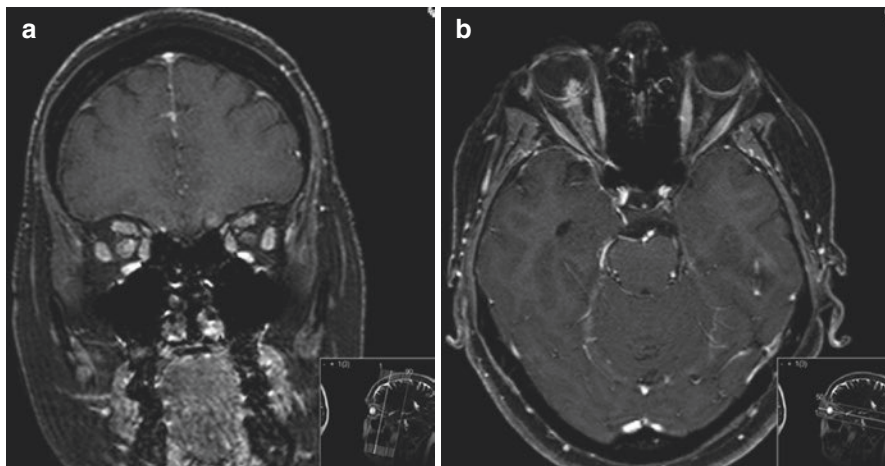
MRI of orbits showing high signal within the right optic nerve – sheath complex extending from the bulbar segment through the optic canal to the chiasm. There is patchy enhancement
